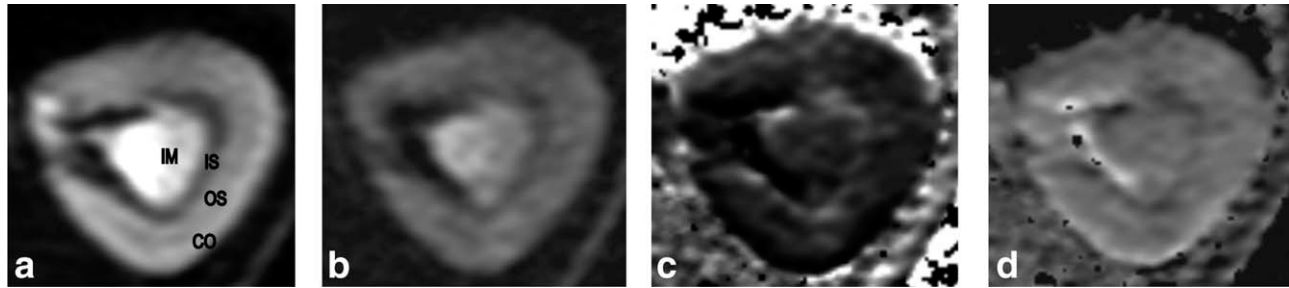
Axial DW-MRI images (2300/70 ms; flip angle, 90°) and ADC measurements in a left kidney. a: The DW image ($b = 0 \text{ s/mm}^2$) obtained in 128×128 matrix with FOV of 8.0 cm provided enough spatial resolution to distinguish four anatomic compartments: the cortex (CO), the outer stripes of the outer medulla (OS), the inner stripes of the outer medulla (IS) and the inner medulla (IM) of kidney. b: DW image obtained at $b = 800 \text{ s/mm}^2$. c: The exponential ADC map. d: The corresponding ADC map.
